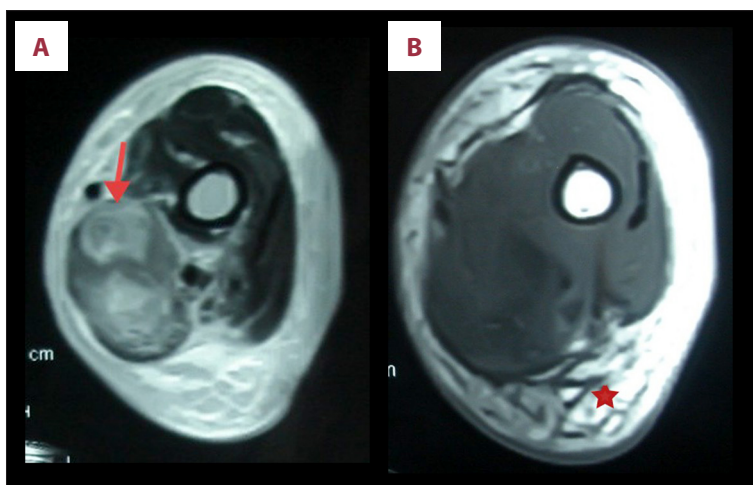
(A, B) First MRI without contrast. Left: Abnormal high signal intensity of biceps in T2 is shown (arrow). Bone marrow and triceps show normal signal. Right: There is remarkable subcutaneous and muscular edema in T1 (asterisk).
